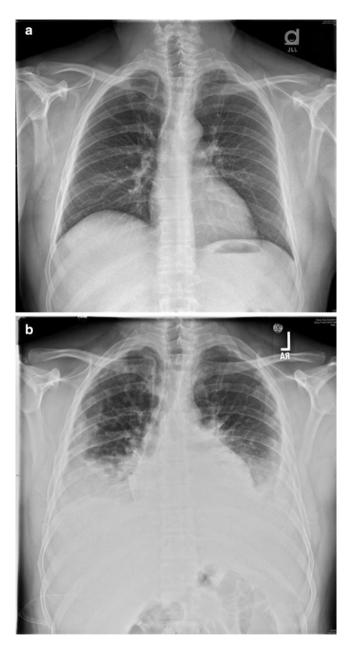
Chest X-rays of rapid development of pulmonary metastases in a high grade leiomyosarcoma of the left groin, (a) pre resection, and (b) 6 weeks post resection recurrence, (2) no known simultaneous distant metastases, (3) the ability, based on radiologic assessment, to anticipate complete removal of all metastasis, and (4) adequate pulmonary function to tolerate resection. Aggressive approaches with unilateral, bilateral, thoracotomy and mediastinotomy were performed.
